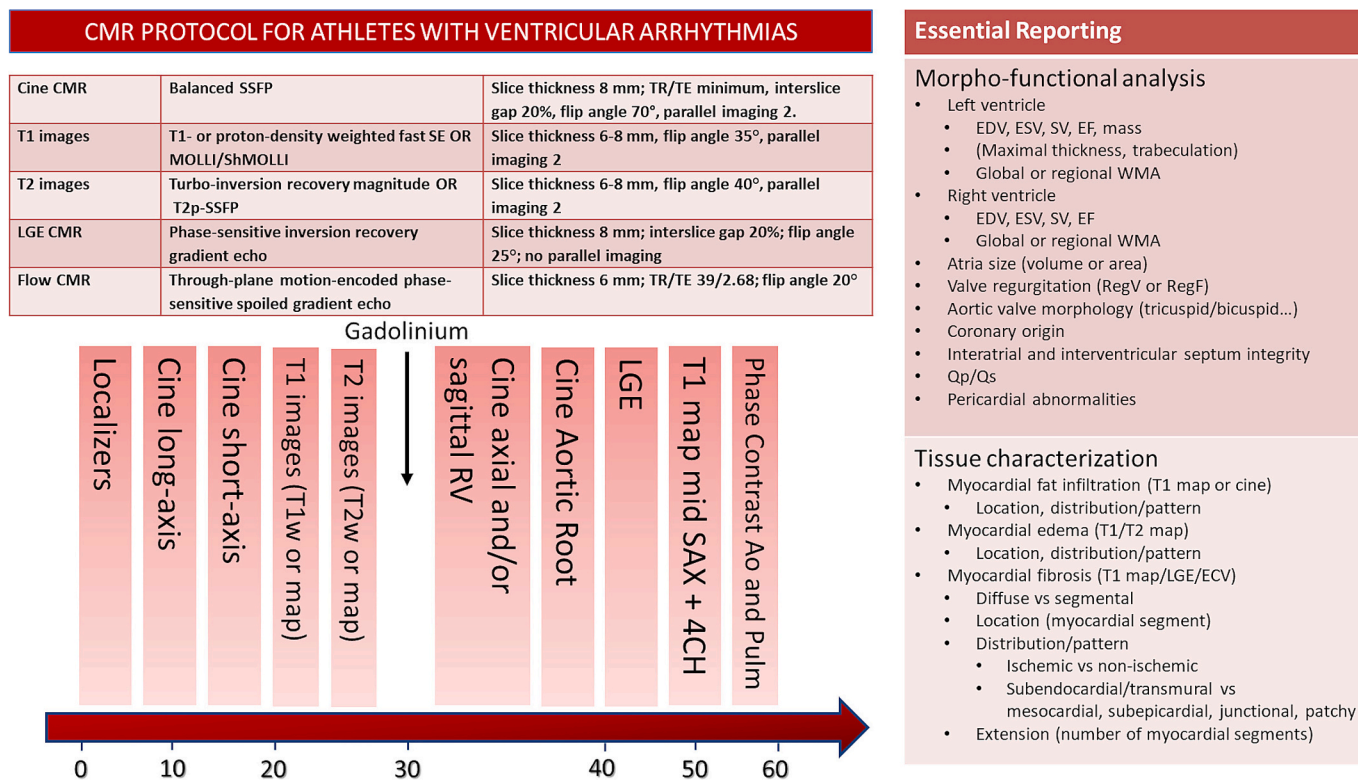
Proposal of protocol of cardiac magnetic resonance acquisition and reporting in athletes referred for ventricular arrhythmias. The sequence protocol should comprise: (1) planning stage including localizer images and general anatomy, (2) cine imaging in long-axis (2Ch, 4Ch, 3Ch) and SAX, (3) T1 and (4) T2 images, cine imaging in axial and/or sagittal view for evaluation for RV kinetics, (6) cine imaging in aortic root, (7) LGE imaging and (8) phase-contrast images. Reference values for evaluation of chamber volumes and T1/ECV in athletes should be used. Abbreviations: CMR = cardiac magnetic resonance; LGE = late gadolinium enhancement; SSFP = steady-state free precession; SE = spin-echo; MOLLI = modified Look-Locker inversion recovery; shMOLLI = shortened modified Look-Locker inversion recovery; T1w = T1-weighted; T2w = T2weighted; SAX = short-axis; 4CH = 4-chamber; Ao = Aorta; Pulm = Pulmonary Artery; RV = right ventricle; EDV = end-diastolic volume; ESV = end-systolic volume; SV = stroke volume; EF = ejection fraction; WMA = wall motion abnormalities; RegV = regurgitant volume; RegF = regurgitant fraction; ECV = extracellular volume.
